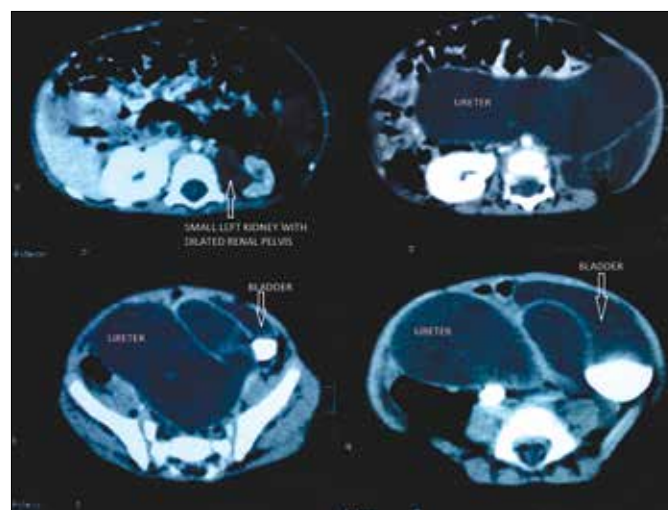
CT scans with a small left kidney, an extremely dilated left ureter and a displaced bladder.
